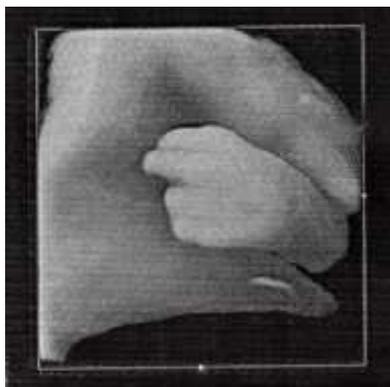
Ultrasoundpicture showing Absent Thumb in left Hand
